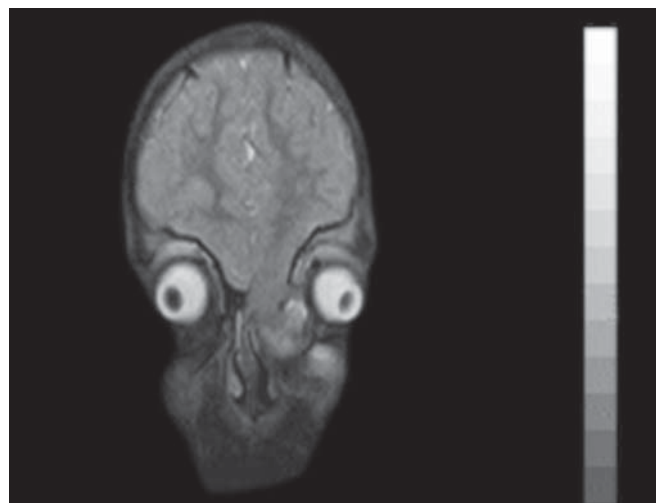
MRI of patient 1
